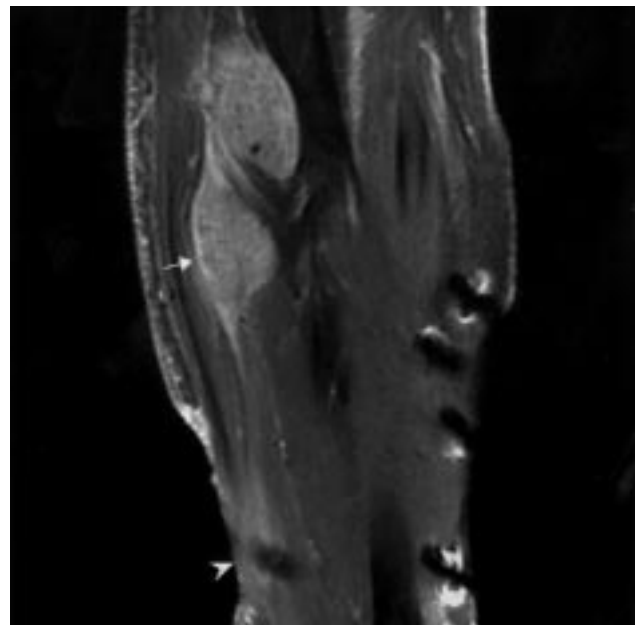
Sagittal, enhanced T1-weighted magnetic resonance image shows a 6 x 5 cm enhanced tumor (arrow) attached to the radial shaft. Normal tissue intervenes between the previous skin graft (arrowhead) and the intramuscular mass. The artifact is due to a surgical clip over the skin graft.
